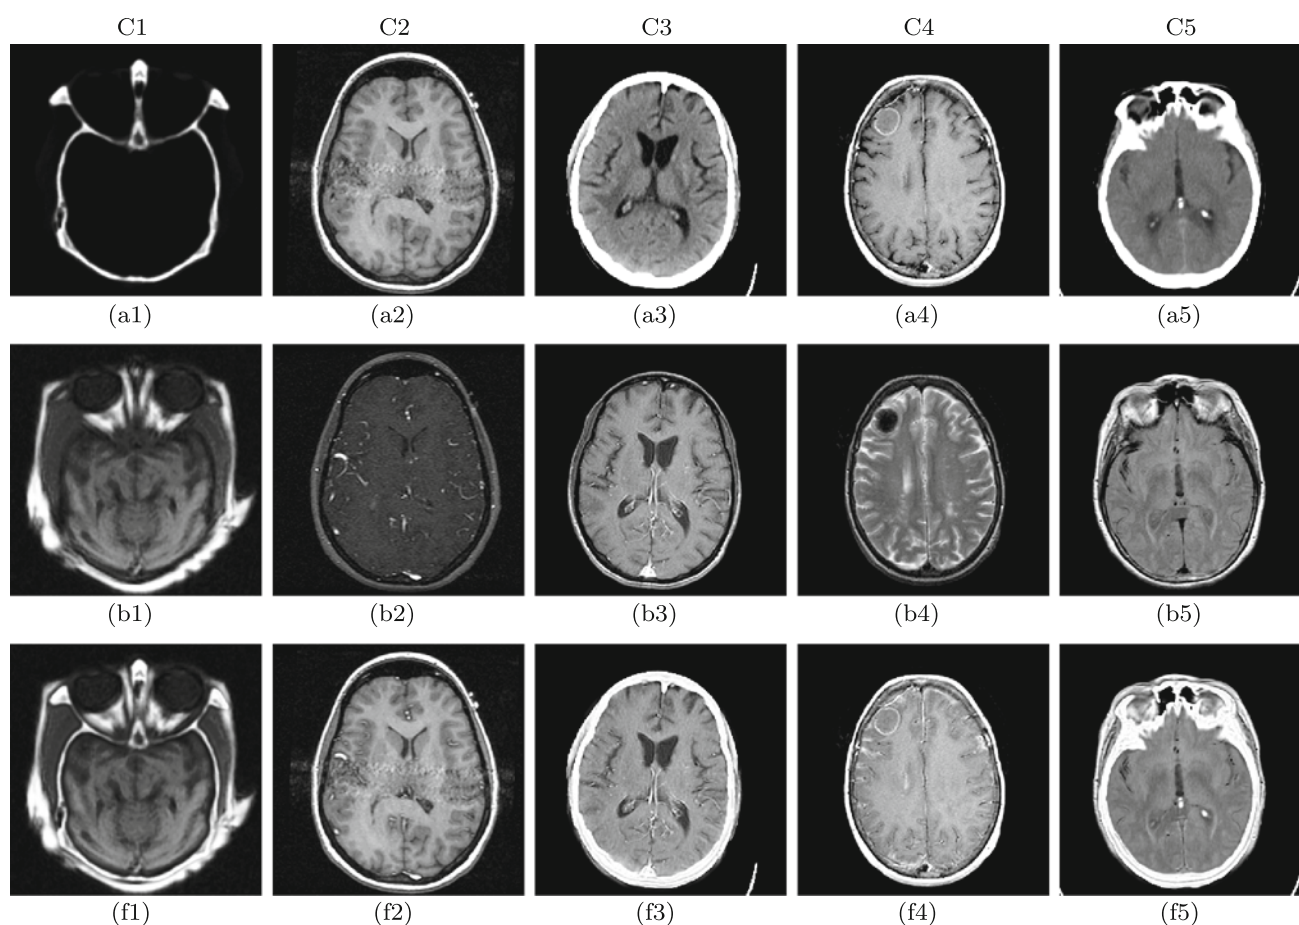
Source images (*top two rows*) with fusion results (*last row*): (source images are downloaded from <http://www.imagefusion.org/>; <http://www.med.harvard.edu/aanlib/home.html>); a1, CT; b1, MRI;
